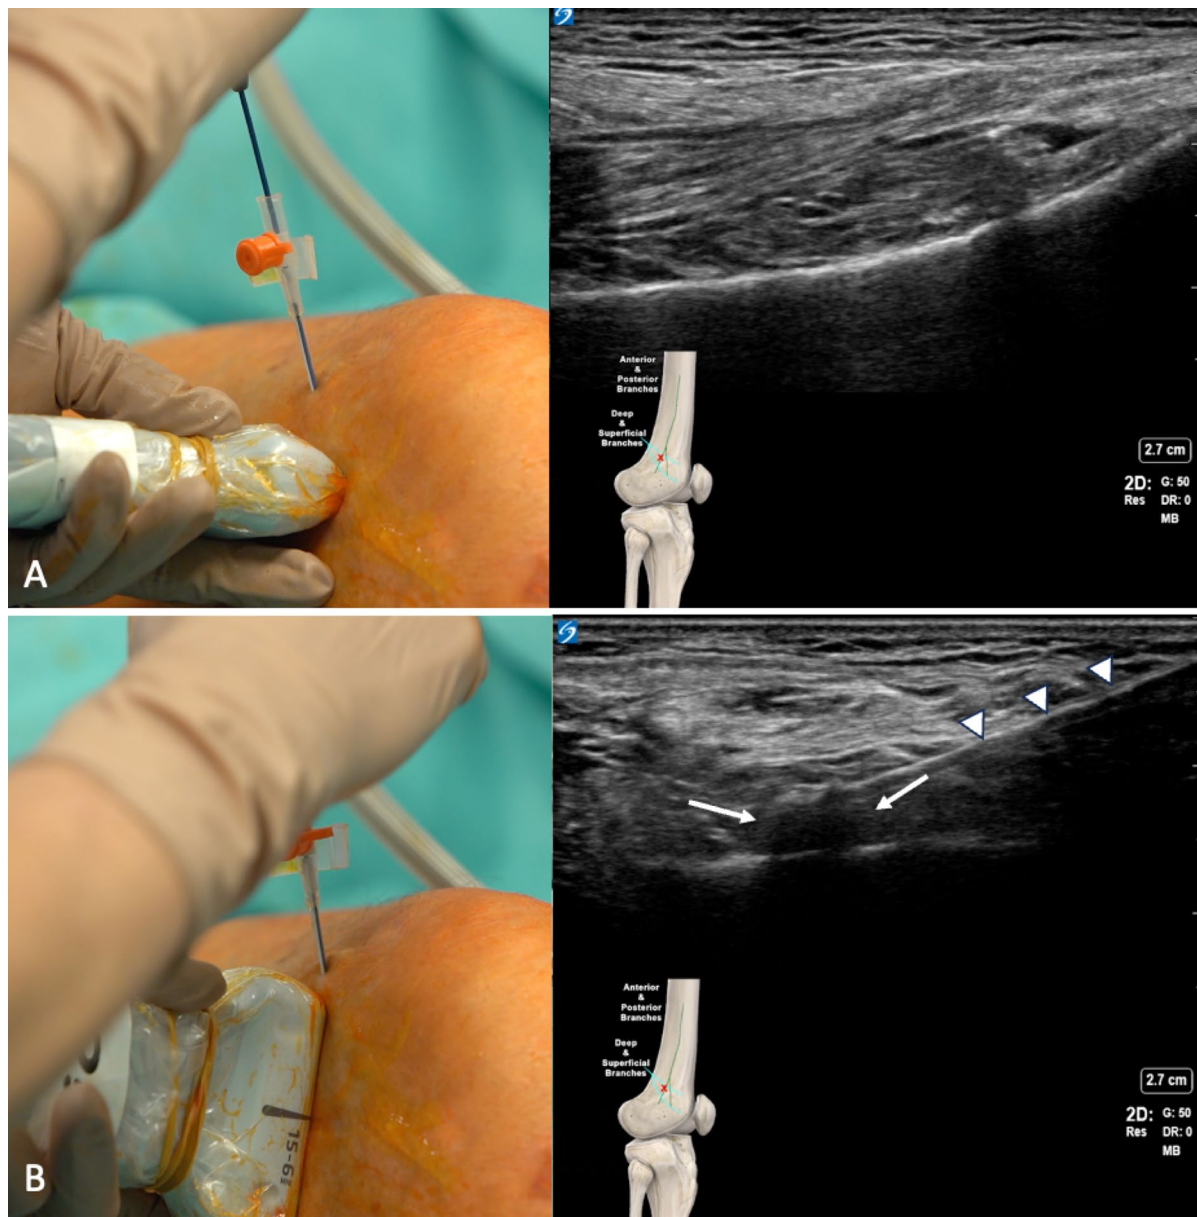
Cryoablation of the superolateral genicular nerves. The cryoprobe is first placed to the junction of the femoral epiphysis and diaphysis, and the bony surface is approached by the cryoprobe (A). Next, the ultrasound probe is rotated 90°, so the cryoprobe is visualized in-plane, as it approaches
